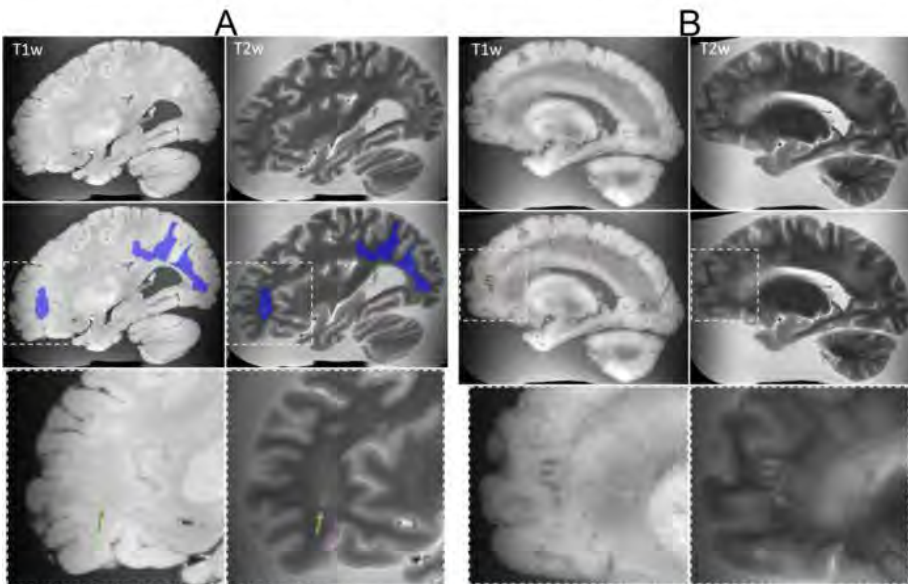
Panel A: (top row) T1w and T2w MRI showing white matter hyperintensities and an infarction. (Middle row) Manual segmentation of the lesions (blue for white matter hyperintensities, green for infarction). (Bottom row) Magnified view of the infarction, indicated by the green arrow. Panel B: (top row) T1w and T2w MRI showing enlarged perivascular spaces. (Middle row) Manual segmentation of ePVS lesions (red). (Bottom row) Magnified view of the ePVS.
